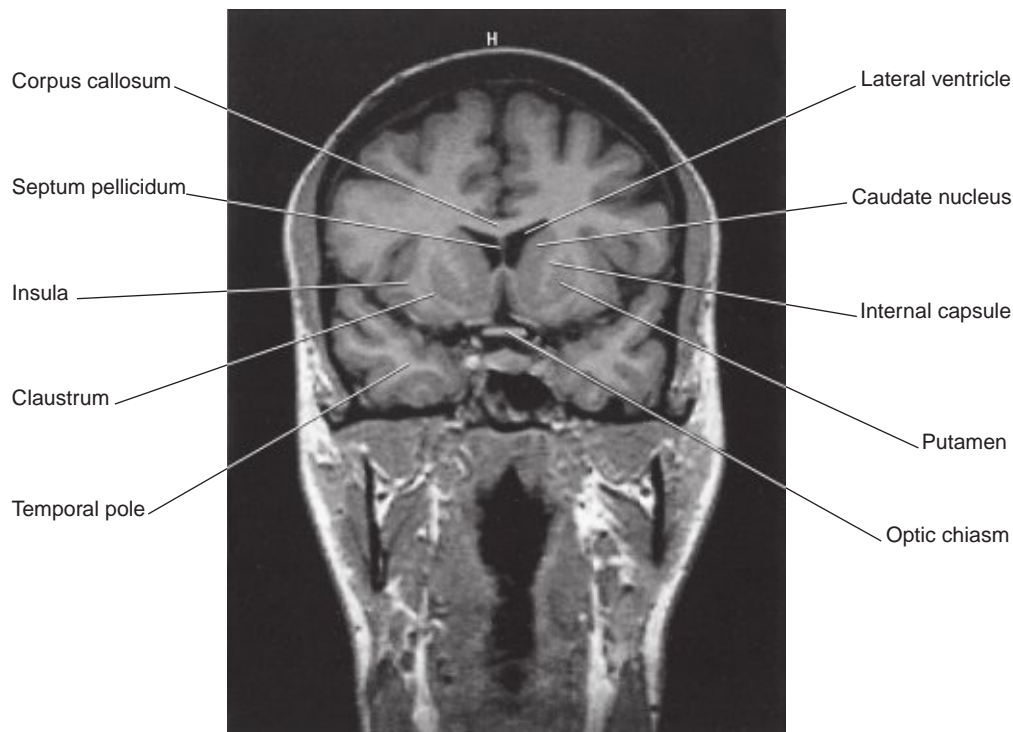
Coronal MRI 'slice' at the level of Figure 2.14. (From a series kindly provided by Professor J. Paul Finn, Director, Magnetic Resonance Research, Department of Radiology, David Geffen School of Medicine at UCLA, California, USA.)
